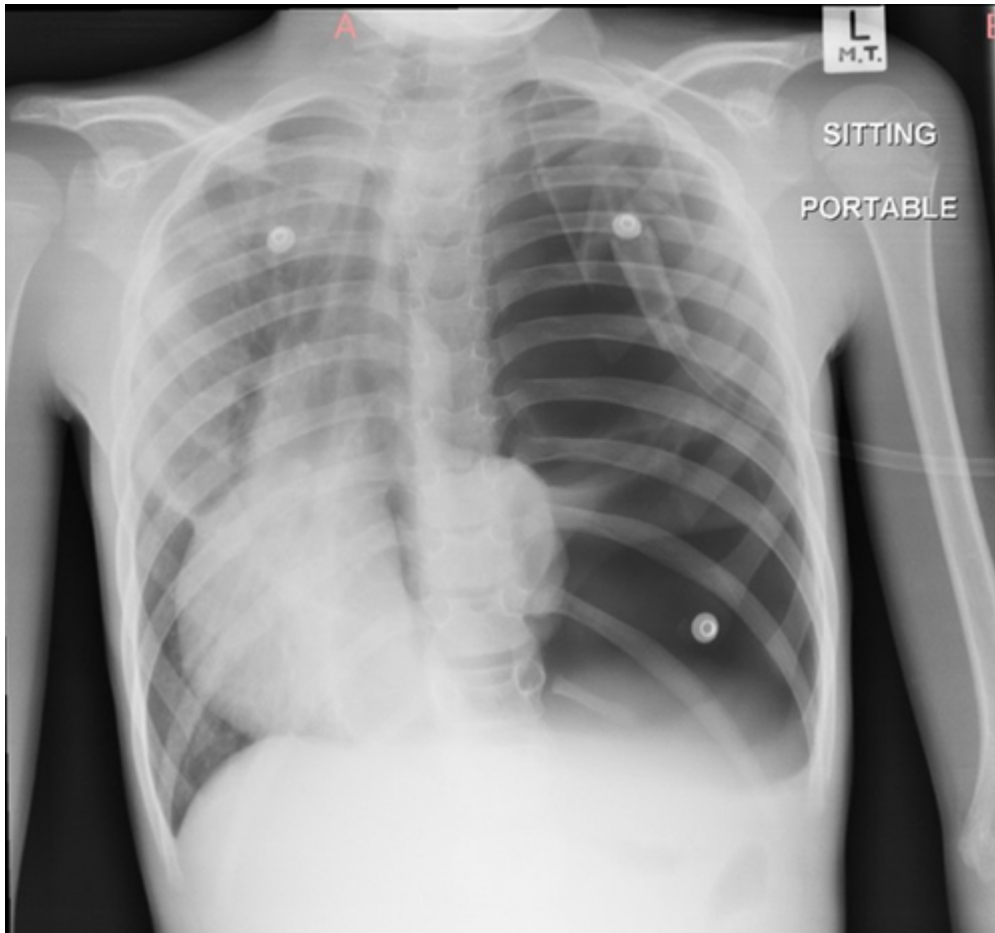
Chest X-ray taken during the first presentation at the referral centre. [↩](#)
